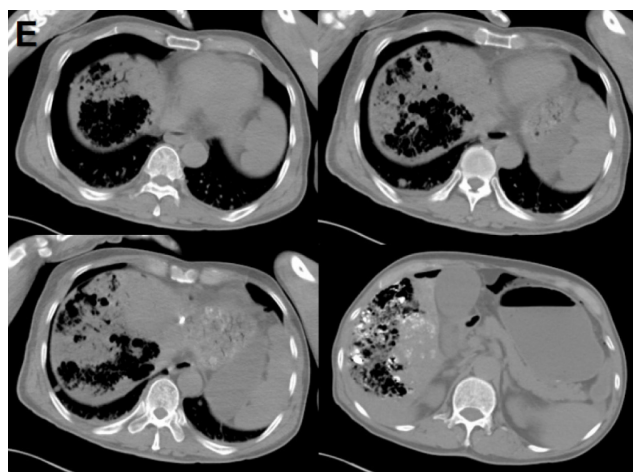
(E) CT examination 3 days after treatment revealed extensive necrosis and cavitation in the liver of patient A.
